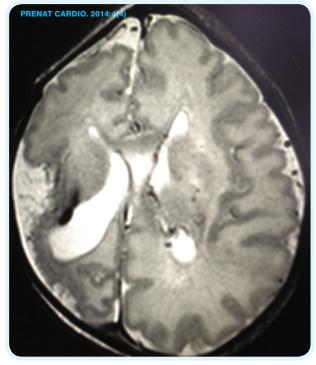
Neonatal MRI 10 days later
